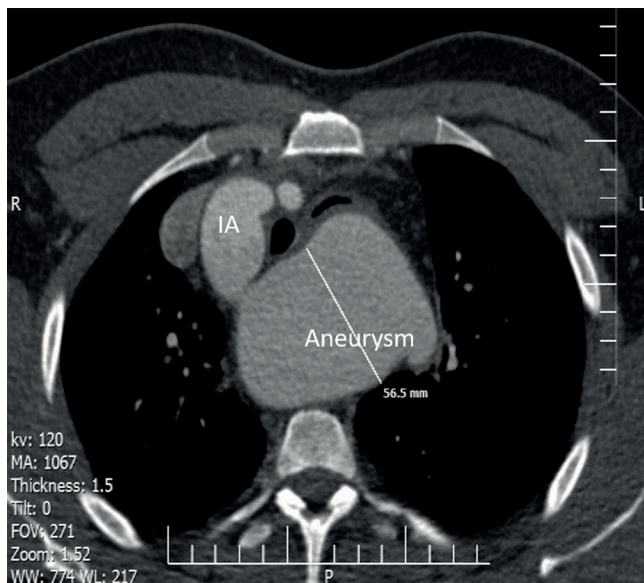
Preoperative computed tomography demonstrates a 6.5 cm arch aneurysm, extending from the origin of the innominate artery to the origin of the left subclavian artery.
